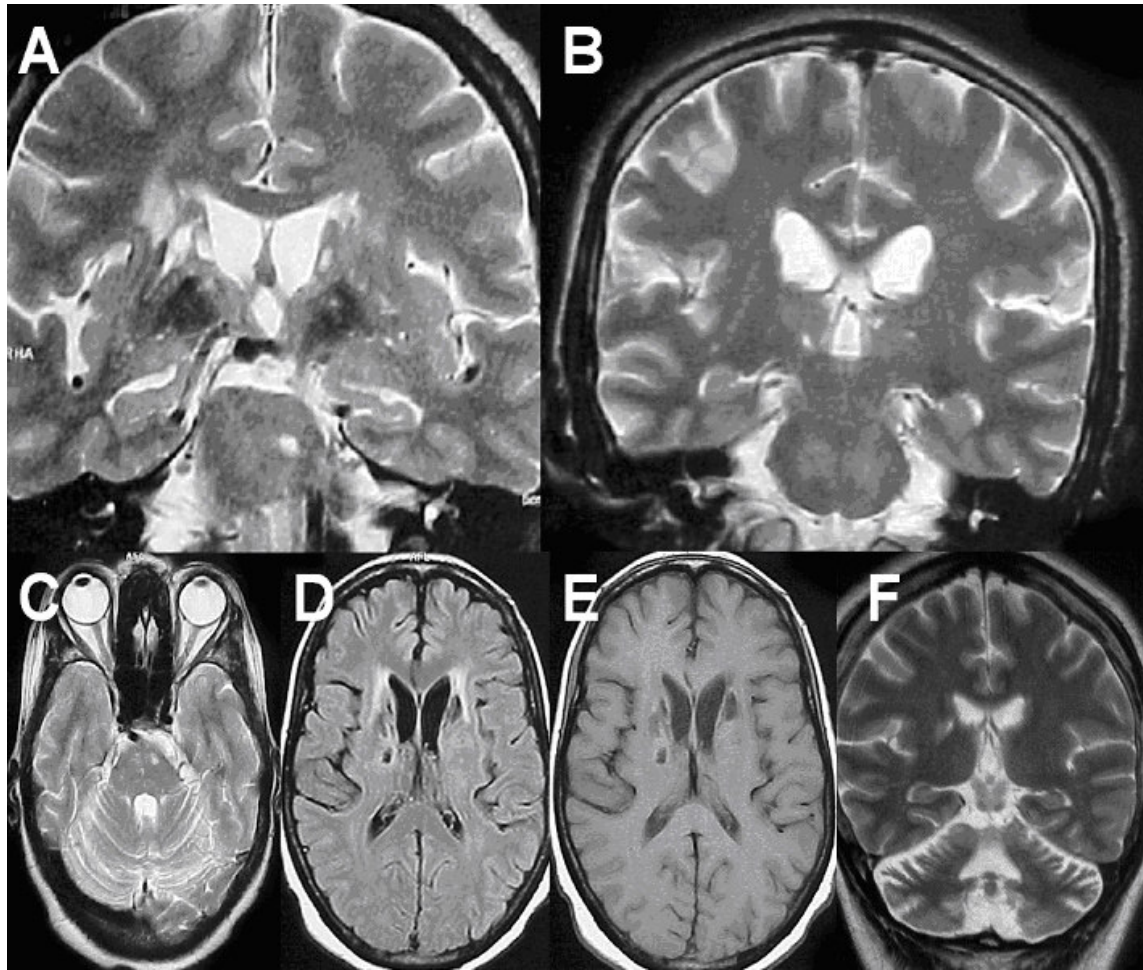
MRI demonstrating lacunes and white matter changes. A: patient B-IV-23 (coronal T2), C (axial T2), D (axial FLAIR), E (axial T1): extensive cavitation of the striatum, thalamus and pons with T2-FLAIR hyperintensity. B: patient A-II-6 (coronal T2) showing lacunar infarctions in the striatum and thalamus. F: patient B-V-10 (coronal T2) showing areas of periventricular T2 hyperintensity.
